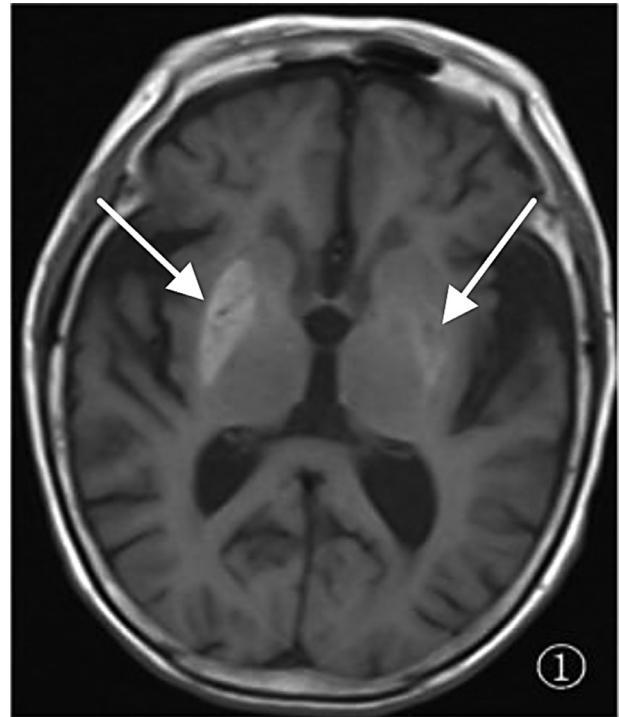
T1WI of Transverse section: High-signal intensity on T1-weighted of bilateral basal ganglia, more obvious on the right side.
